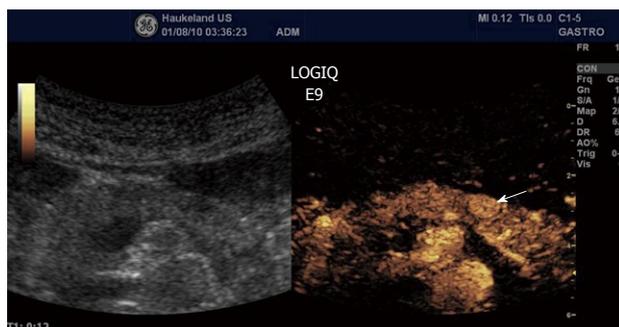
Neuroendocrine tumour (arrow) shows a rapid intense enhancement in the early arterial phase of contrast-enhanced ultrasound examination.
